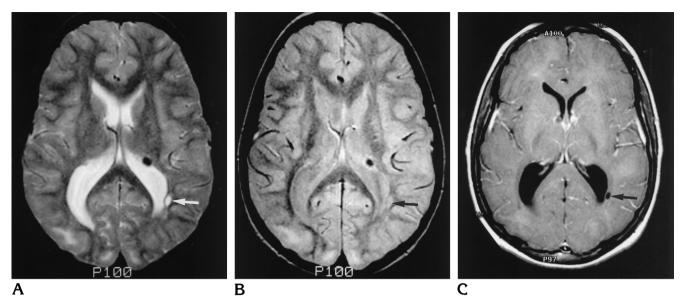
T2- (A) and proton density– (B) weighted spin-echo images show a cystlike lesion near the left occipital horn (*arrow*) that follows cerebrospinal fluid signal intensity. Bilateral cortical tubers are also seen. Contrast-enhanced T1-weighted image (C) with slightly different angulation shows isointense signal in the cyst and ventricle. Subependymal tubers at the foramina of Monro are also seen.
